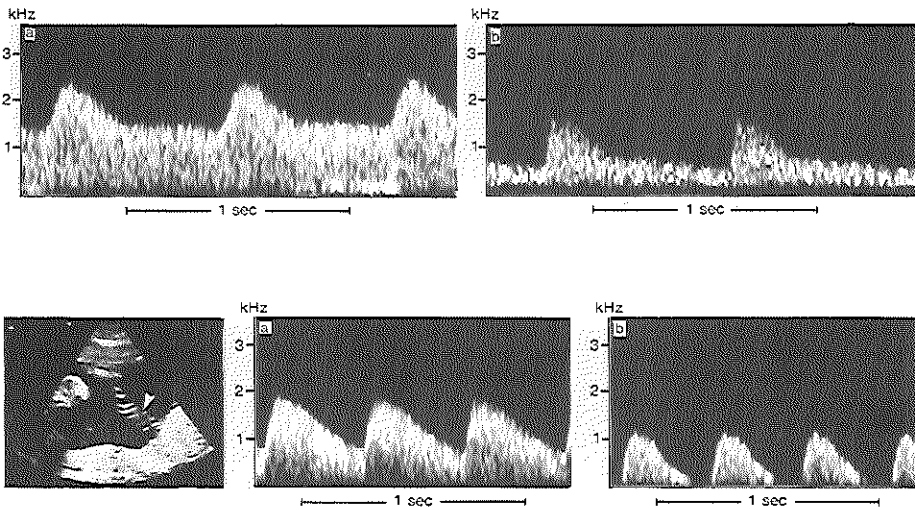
Top panel: Doppler flow velocity waveform tracings from a uteroplacental vessel during normal pregnancy (a) and intrauterine growth retardation (IUGR) (b). Bottom panel: Two-dimensional transverse cross section of the pregnant uterus with Doppler flow velocity waveform tracings from the umbilical artery (arrow indicates umbilical cord) during normal pregnancy (a) and IUGR (b).
